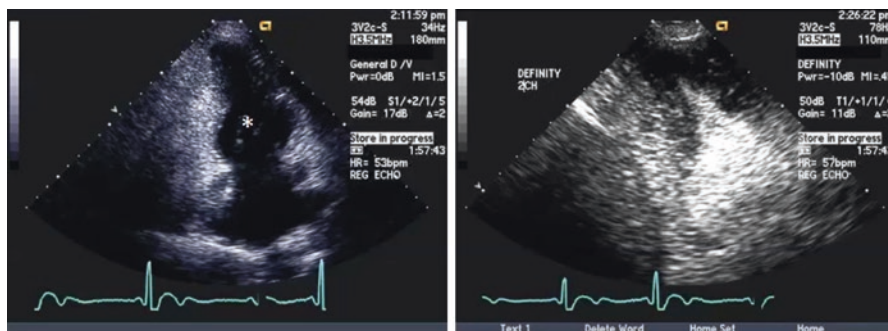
Apical two-chamber view. Asterisk shows the typical “spade” shape ventricular cavity characteristic of apical hypertrophic cardiomyopathy
